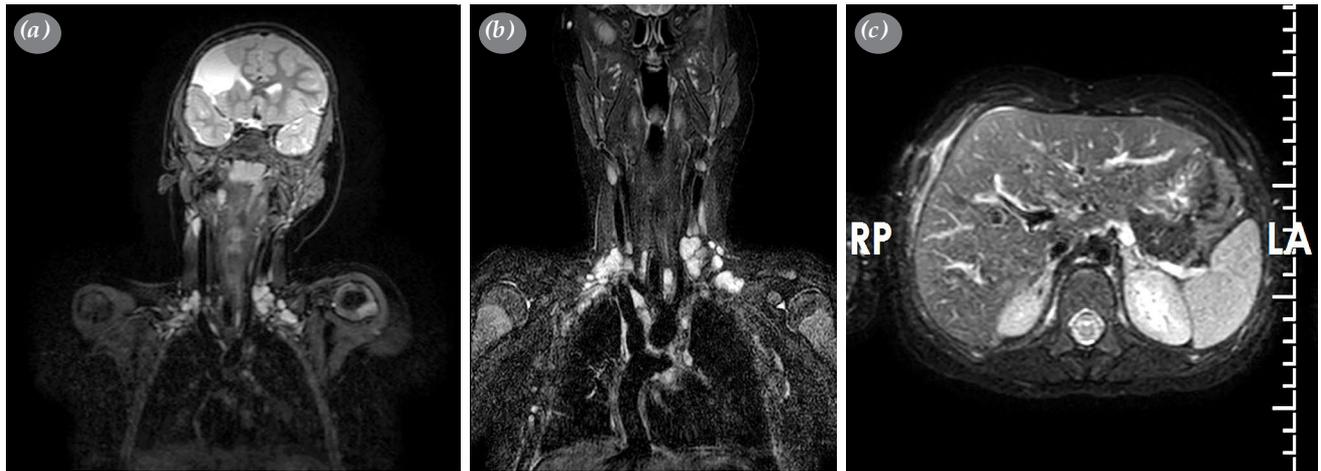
(a) T2-weighted imaging shows abnormally increased lymphatic channels in the supraclavicular region that do not extend into the mediastinum. (b) Lymphatic expansions reaching both supraclavicular regions and the mediastinum as seen by T2-weighted magnetic resonance imaging lymphangiography. (c) T2 hyperintensity signal changes seen in axial cross-section in pleura and retroaortic region.
